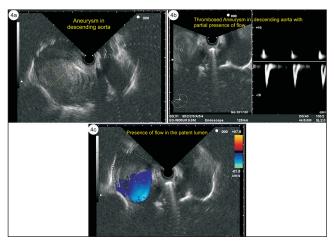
(a) Aneurysm with a large thrombus in the descending aorta (b) EUS image of thrombosed aneurysm (c) Doppler EUS image of aortic dissecting aneurysm
